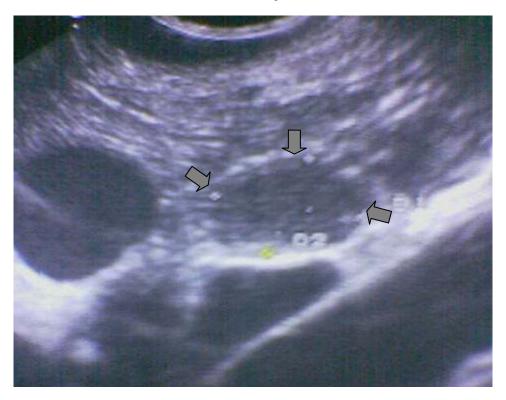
Endoluminal ultrasound revealed that there is mass related to the head/neck region of the pancreas about 1.5 cm in diameter.
